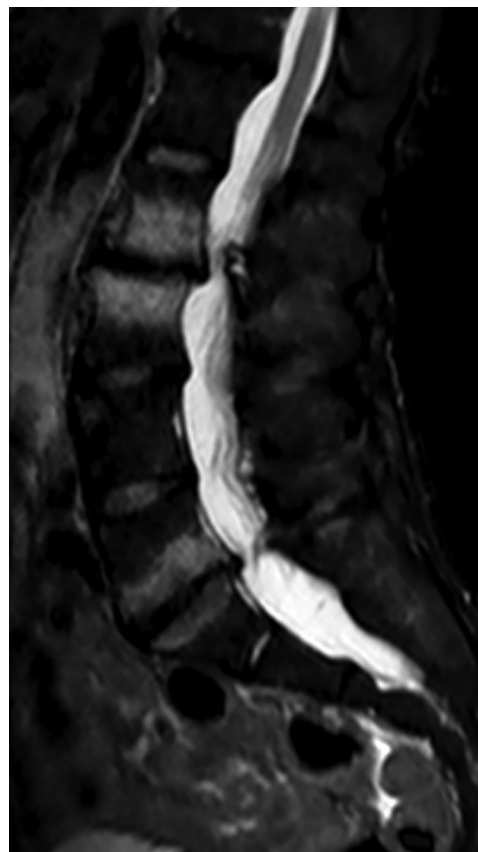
Magnetic resonance imaging shows scoliosis and advanced spondyloarthrosis in a 51-year-old man with autosomal dominant polycystic kidney disease and stage 2 chronic kidney disease.
